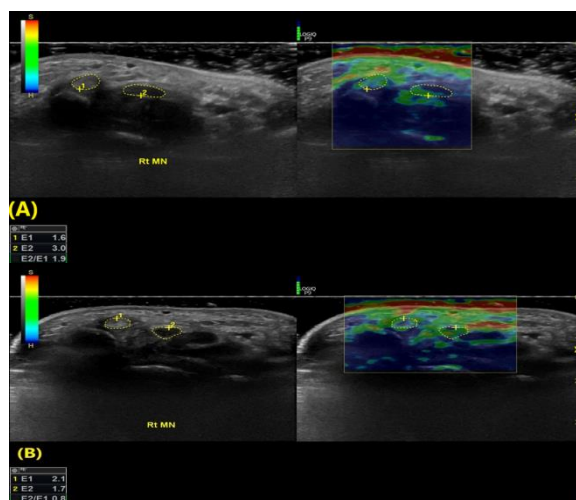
B-mode ultrasonographic and sonoelastographic images of the median nerve in the transverse plane at carpal tunnel inlet. (A) 38-year-old female patient with mild carpal tunnel syndrome, (B) 25-year-old female healthy volunteer.
